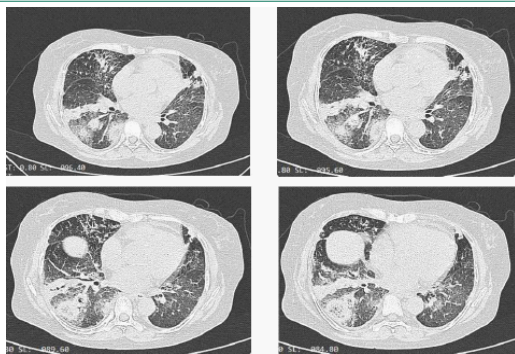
HRCT chest images showing reverse halo sign (Atoll sign).
